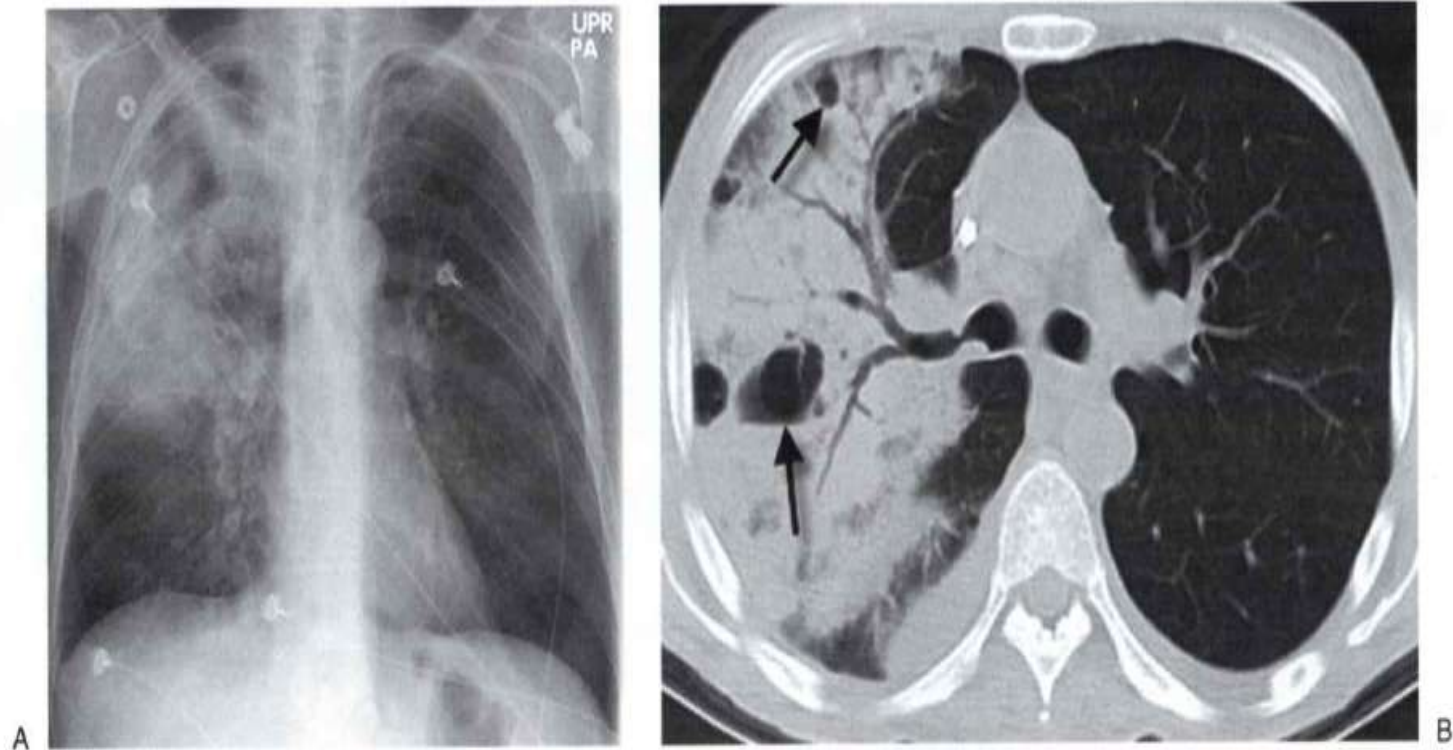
Necrotizing *Pseudomonas* pneumonia. A: PA chest radiograph shows ALD in the right upper and middle lung. B: CT shows numerous lucent areas with air-fluid levels (arrows) within the densely opacified lung, consistent with lung necrosis. Also shown are prominent air bronchograms.
